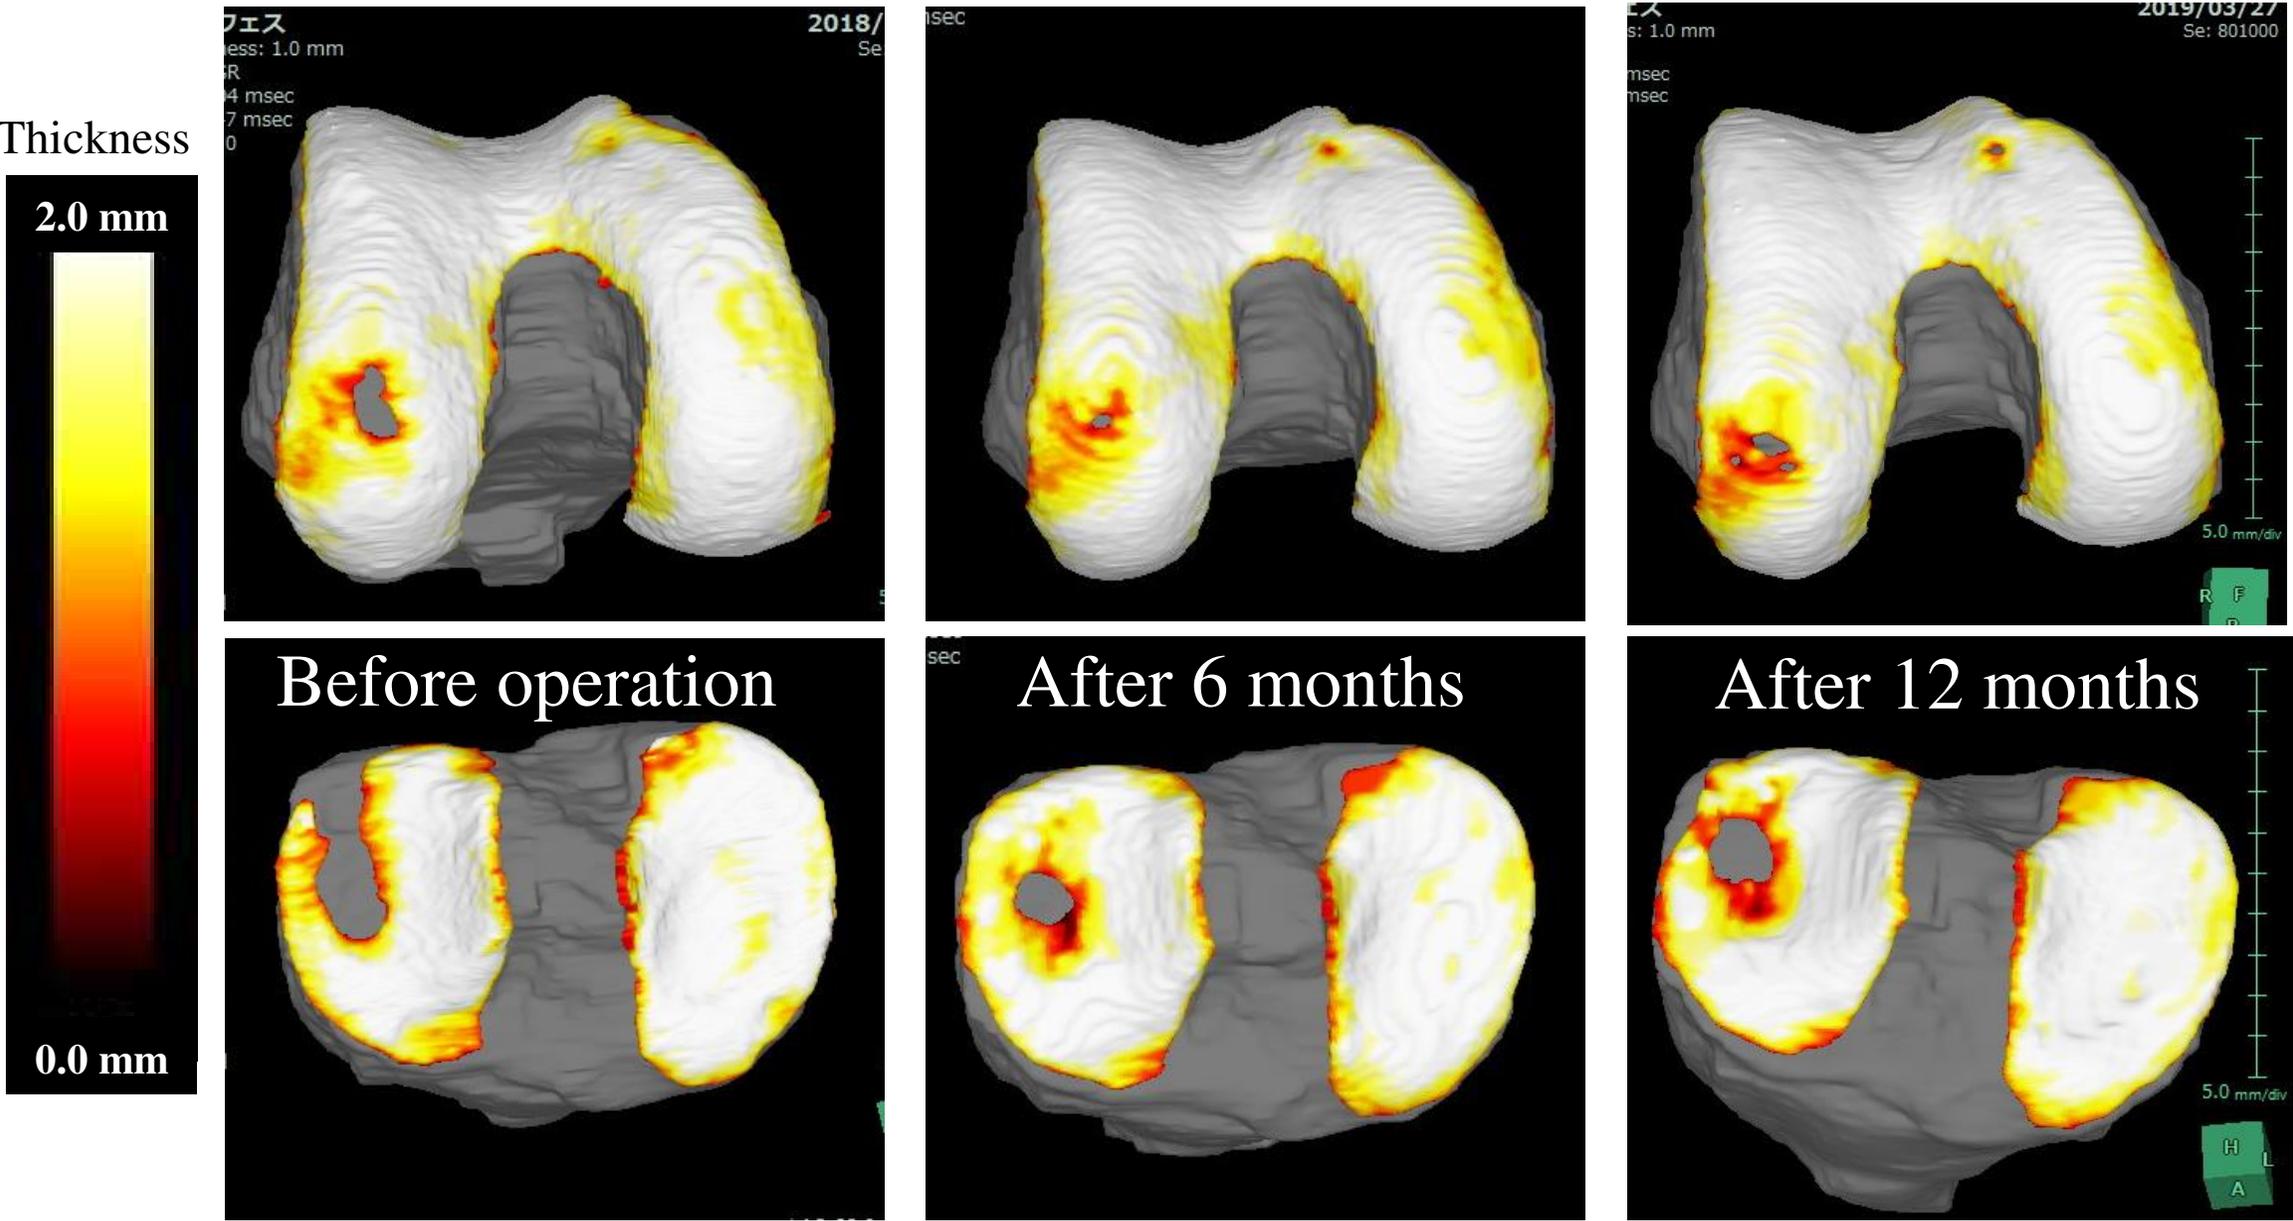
Clinical course of cartilage thickness evaluated by MRI (3D image rendered by VINCENT)
